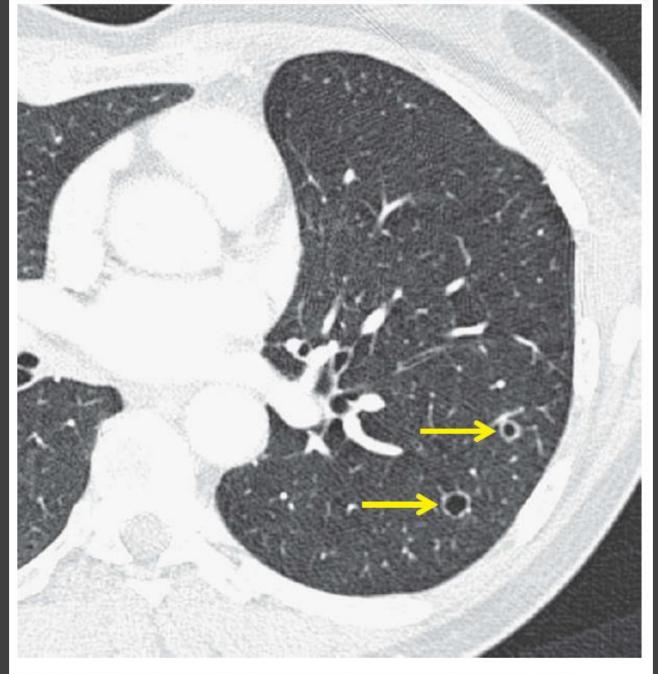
CT of cavitating metastasis from squamous cell carcinoma (arrows). Hansell Imaging of Diseases of the Chest. 5th Ed
